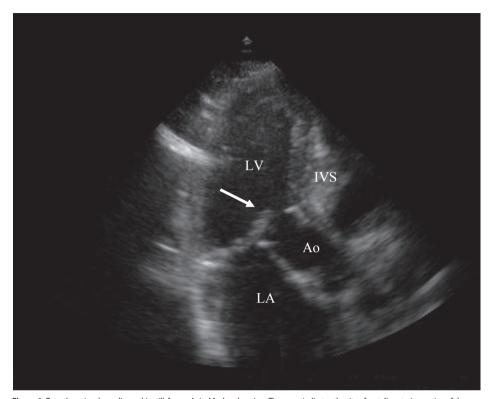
Transthoracic echocardiographic still-frame. Apical 3-chamber view. The arrow indicates the site of systolic anterior motion of the anterior mitral valve leaflet. Outflow tract obstruction is created in the presence of septal hypertrophy and systolic anterior motion. Ao = Aorta Ascendens. IVS = InterVentricular Septum. LA = Left Atrium. LV = Left Ventricle.
